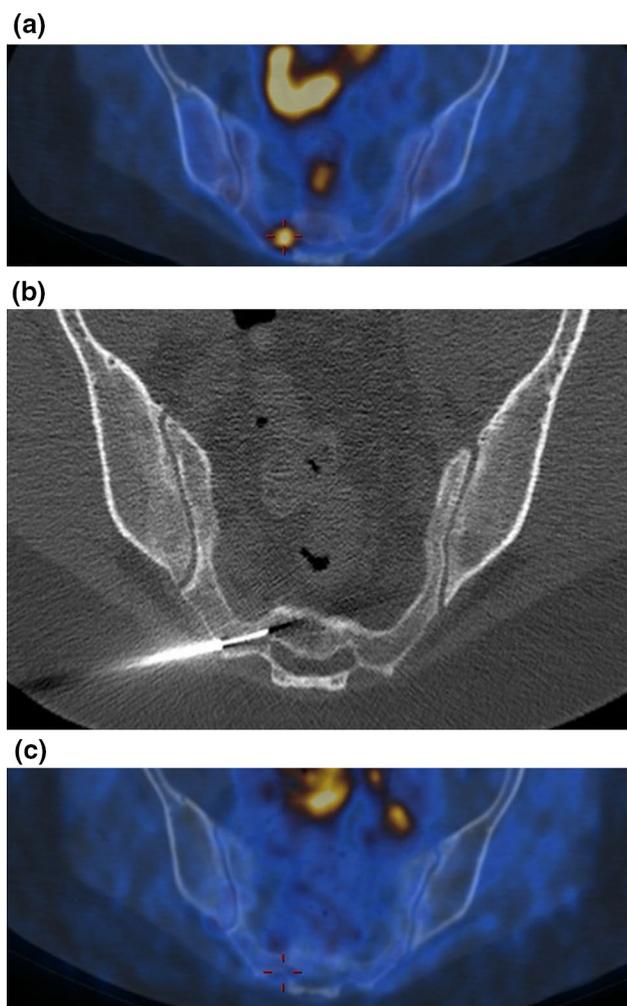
a PET–CT scan shows a sacral bone metastasis in a 52-year-old woman with thyroid cancer. b CT-guided radiofrequency thermal ablation was done. c Complete normalization of the PET–CT 6 months after treatment
